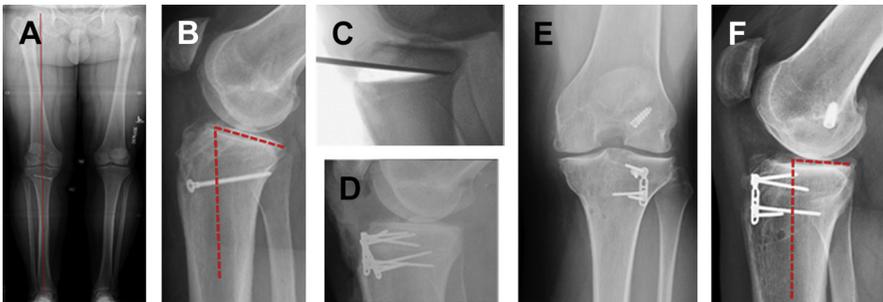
A 22-year-old basketball player presented with right knee pain and recurrent giving way episodes. Surgical history consisted of 3 failed ACL reconstructions, and physical examination demonstrated high-grade Lachman and pivot shift. (A) AP radiograph showing normal coronal alignment. (B) Lateral radiograph showing increased posterior tibial slope of 25° . Additional computed tomography (CT) and MRI findings were large bony tunnels defects, medial meniscus deficiency, and lateral meniscus radial tear. A t2-stage revision was decided. The first stage included anterior proximal tibial closing wedge osteotomy, tunnel bone grafting, and lateral meniscus repair, and the second stage included ACL revision and medial meniscus transplantation. (C) Intraoperative fluoroscopy showing opening of anterior wedge. (D) Lateral radiograph after the first stage. (E) AP radiograph after the second stage. (F) Lateral radiograph after the second stage showing corrected posterior tibial slope of 7° .
